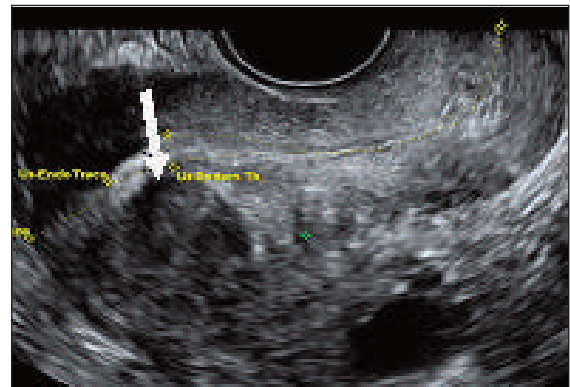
2D ultrasound of fibroid and peripheral vascularity of fibroid seen on power doppler.
